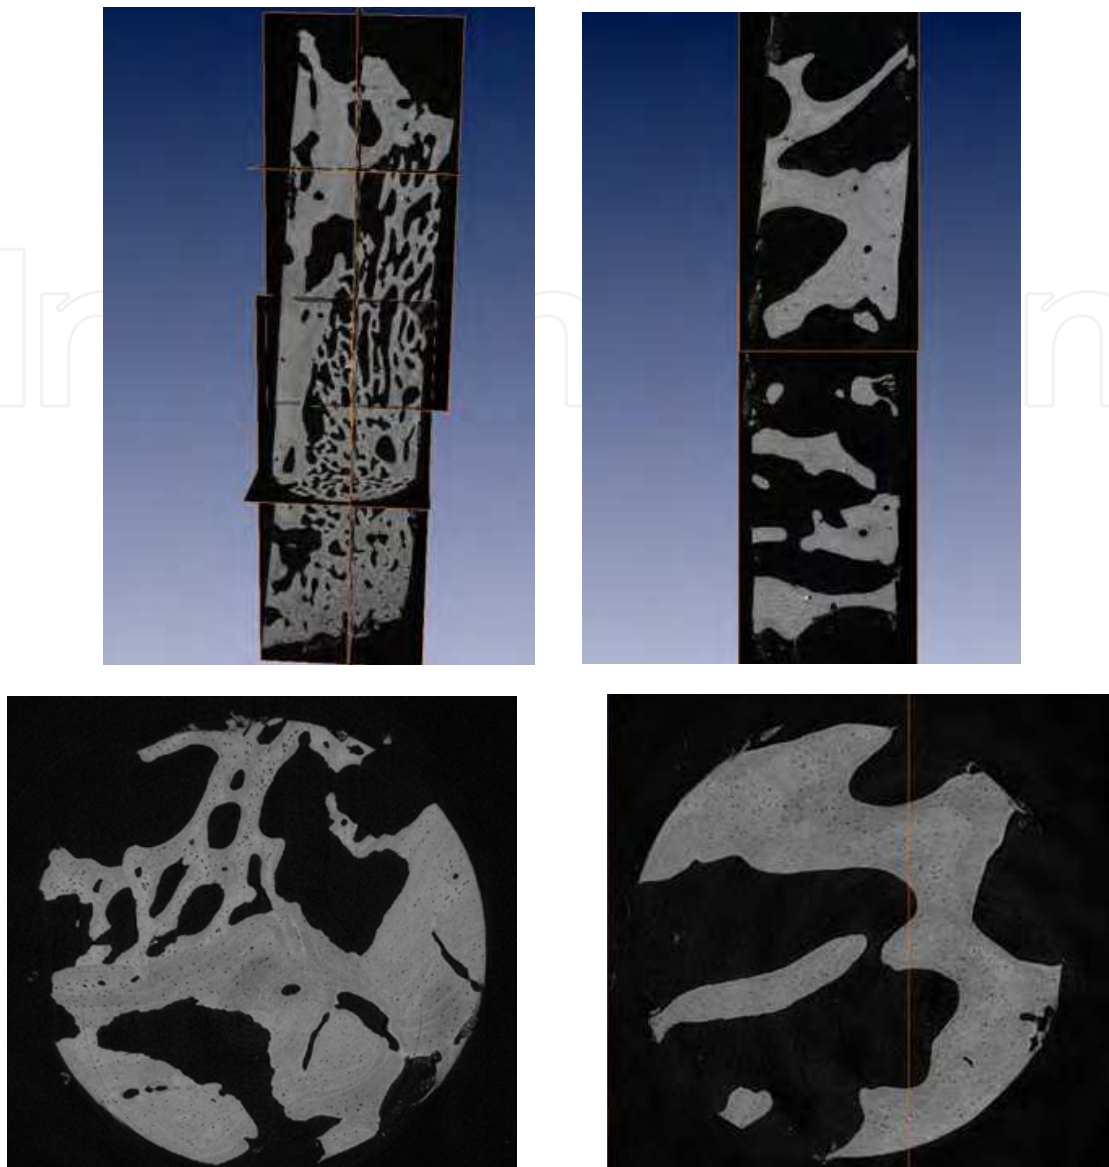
Axial and orthogonal cuts showing the different grades of mineralization and osteocytes location for a healthy (fr2) and an osteoporotic (fr7) bone biopsy of the jaw region36 after SR-CT measurements @ 2.174  $\mu\text{m}$  (BESSY).
